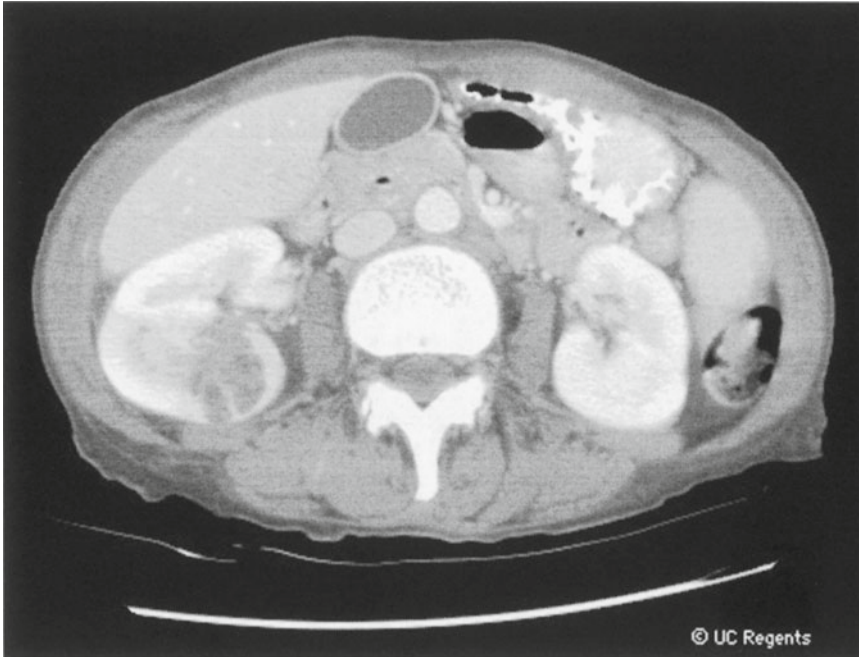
Contrast-enhanced CT demonstrating evidence of right pyelonephritis and abscess formation. Note the posterior region of reduced attenuation, consistent with pyelonephritis, and the multiple septae within the abscess
